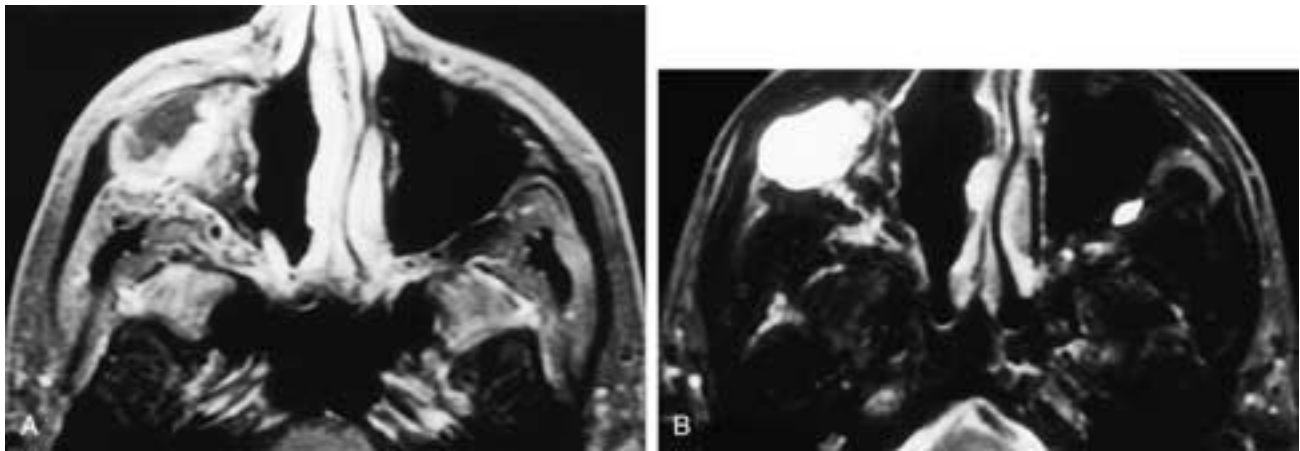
Axial T1-weighted (A) and T2-weighted (B) MR images on a patient who had a right medial maxillectomy. There is a nonhomogeneous inflammatory-type collection in the zygomatic region of the remaining sinus cavity. The medial portion of this cavity remains well aerated. This patient had a postoperative right maxillary sinus mucocoele.
